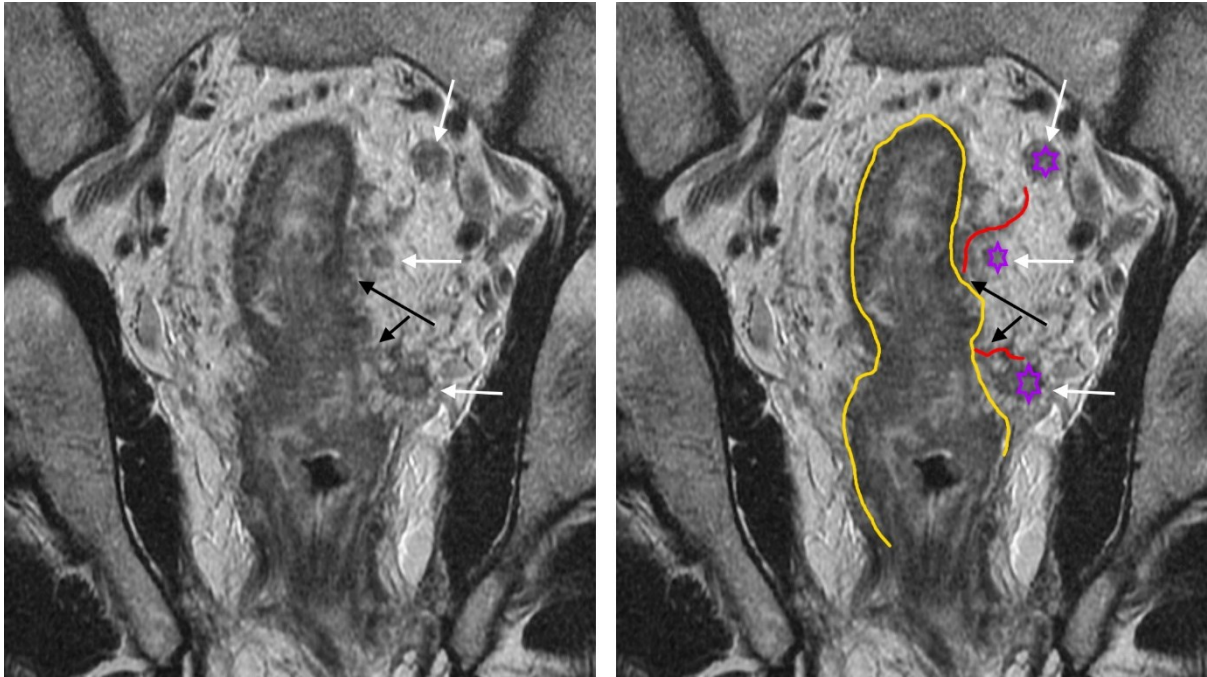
High resolution T2-weighted coronal oblique MRI of a locally advanced rectal cancer with large vessel EMVI and ENTDs consistent with N1c disease.
